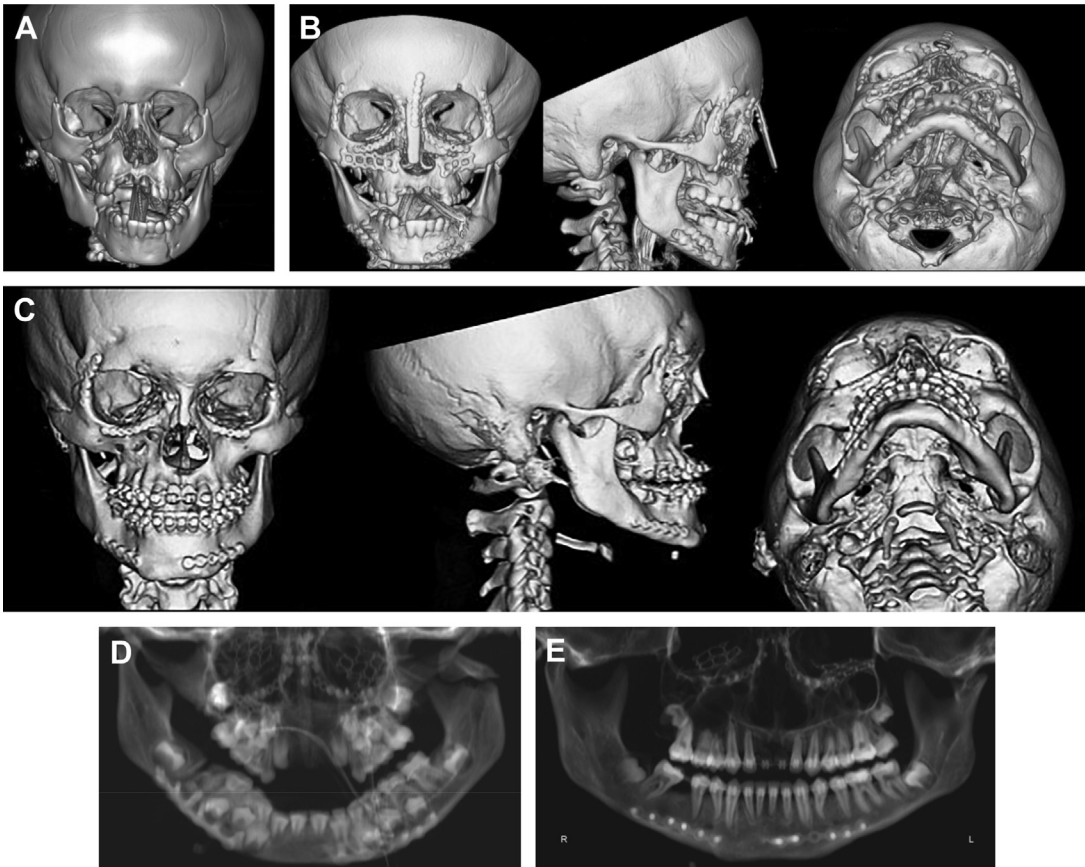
(A) Contemporaneous panfacial presentation. A 6-year-old girl involved in an MVC presenting with significant injuries to the occlusal unit while sparing the frontobasilar region. Preoperative CT imaging is notable for displaced bilateral LeFort 1/2/3 fractures and 4-piece mandible with severely displaced right body, minimally displaced left parasymphysis, and displaced left subcondylar fractures. (B) Immediate postoperative fracture fixation. Through a top-down, outside-in approach, she underwent open reduction and internal fixation (ORIF) of bilateral zygoma fractures from to restore facial width followed by bilateral orbital floor reconstruction using titanium mesh implants to correct orbital dystopia and ORIF of bilateral NOE fractures with cantilever reconstruction of the nasal dorsum using split cranial bone graft to restore central midfacial projection. Next, she underwent spanning ladder plate reconstruction of the maxilla from the zygomatic body to the nasomaxillary buttresses to restore midfacial weight and set the midfacial height. Finally, she underwent ORIF of her right mandibular body fracture using inferior border and tension band plates through an extraoral approach to control for lingual splay and ORIF of his left mandibular parasymphyseal fracture through an intraoral approach. Given the inherent benefit of the top-down approach and general avoidance of the condylar growth center, the displaced left subcondylar fracture was managed nonoperatively. Conventional titanium plate fixation systems were utilized. (C) Interval growth. CT imaging obtained at 12 years of age, nearly 6 years postoperatively demonstrates interval facial growth with significant healing and remodeling. Note removal of the lower midfacial fixation plates and mandibular tension bands at 8 years of age, approximately 2-year postoperatively. (D) Immediate postoperative dentition. Note the placement of inferior border plates along the mandible with monocortical fixation to avoid the developing dental follicles. Note the lack of consistent paranasal sinus aeration with unerupted maxillary dentition. Note the position of the displaced left subcondylar fracture, which was left to remodel. (E) Dental development into permanent dentition. At 12 years of age, nearly 6 years postoperatively, panoramic radiograph demonstrates extensive bony remodeling along the mandibular fractures with largely uninterrupted eruption of the permanent maxillary and mandibular dentition. Note some flattening of the left condylar head and mild vertical discrepancy along the ramus condyle unit.
